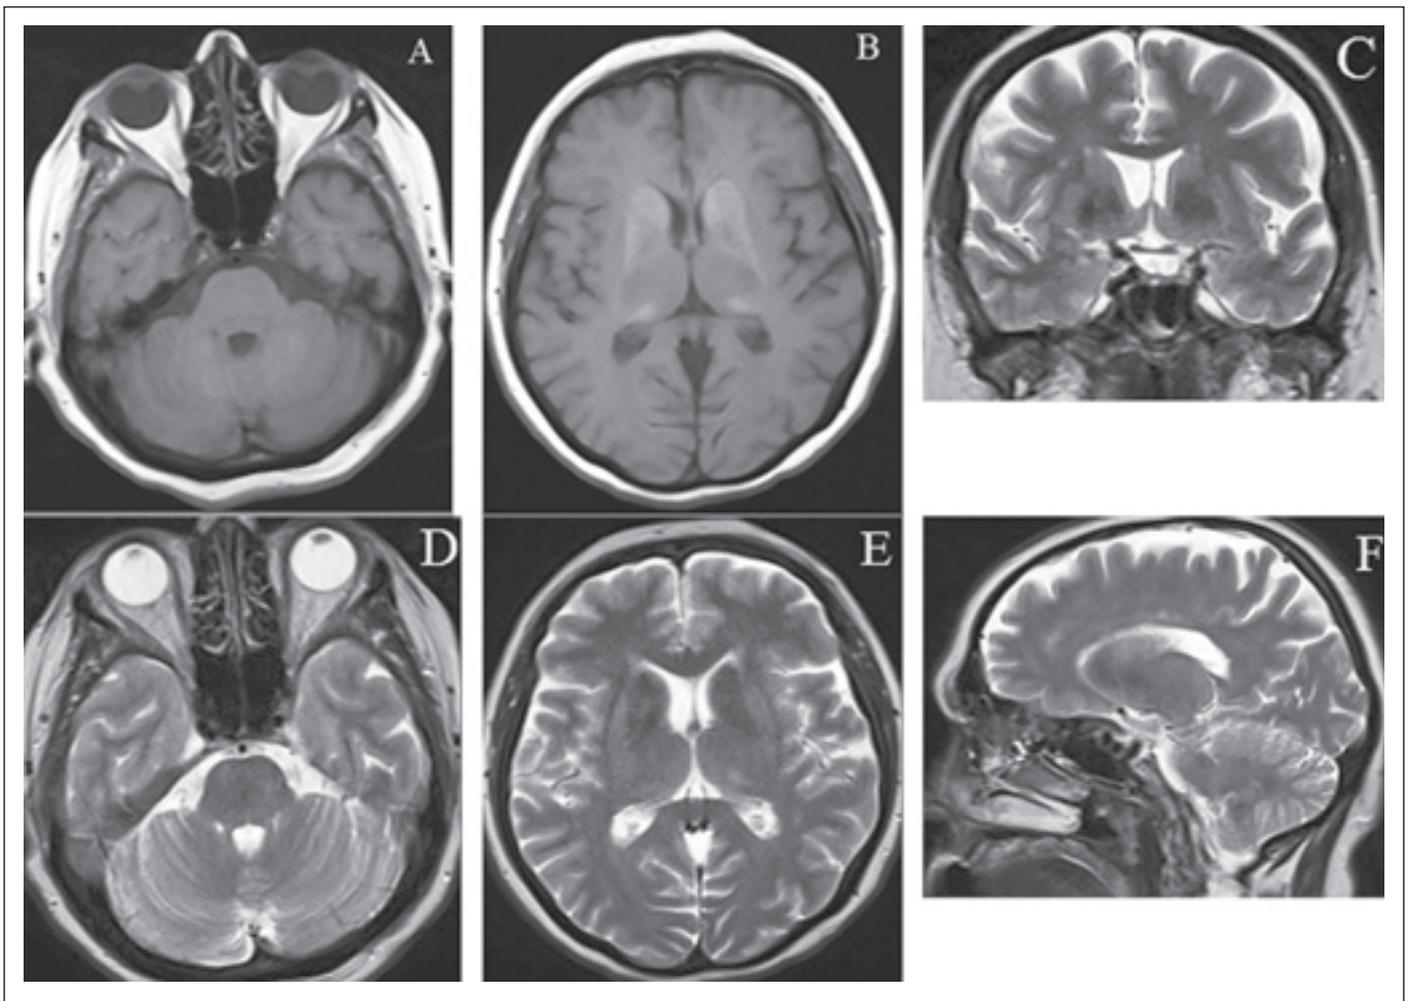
Brain MRI. (A, B) Axial T1-WI images showing bilateral symmetric hyperintense areas, (C) coronal T2-WI, (D, E) axial T2-WI, (F) sagittal T2-WI showing bilateral symmetric hypointense areas.
